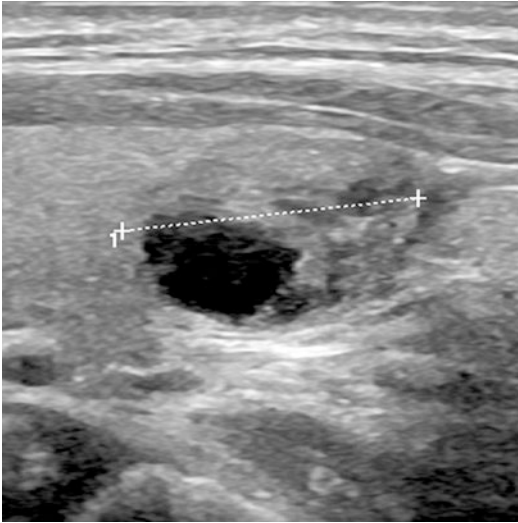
A predominantly solid without suspicious sonographic features such that it can be safely diagnosed as benign on ultrasound. Even when hypofunctioning on TS such nodule needs no FNAC for further risk assessment since the finding is explained by the relevant cystic component in this case
